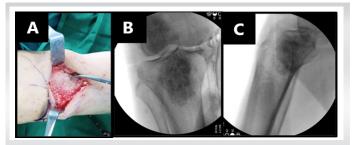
Intraoperative images (a). Bone defect completely filled by a well-impacted allograft. (b). Plain radiograph in AP views showing a well-filled bone defect. (c). Plain radiograph in lateral view showing a well-filled bone defect.
